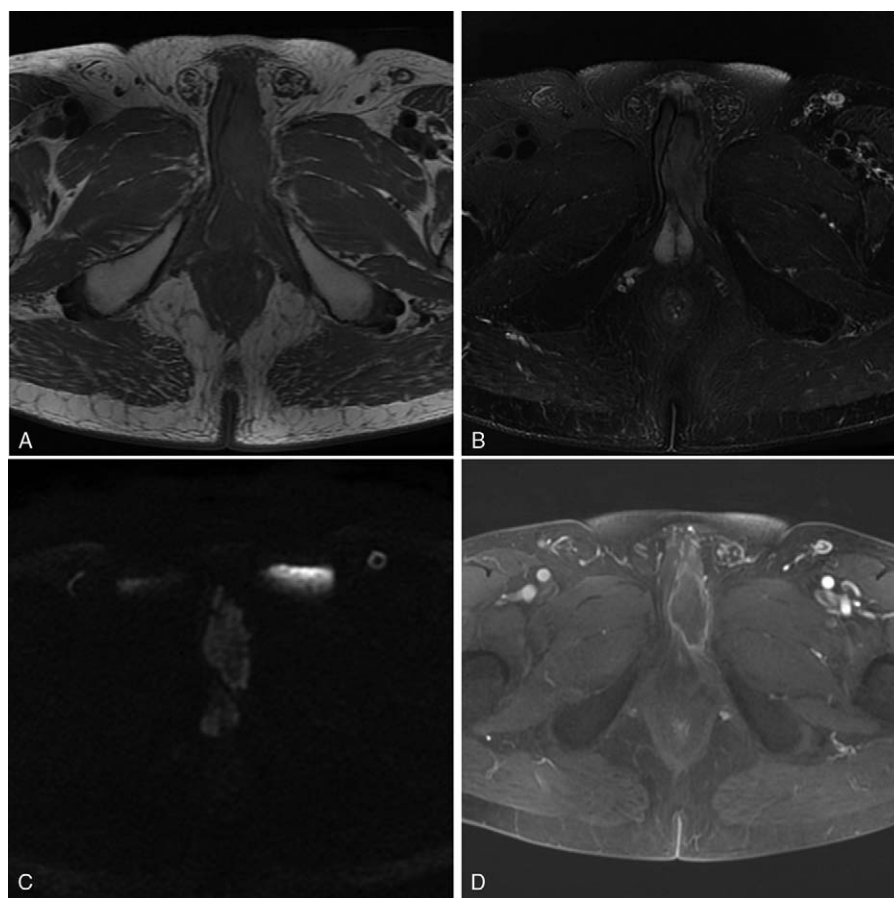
MRI of the pelvis: (A) T1-weighted image shows an isointense tissue mass located at the base of the left corpora cavernosa with irregular margins. (B) T2-weighted image shows slightly hyperintense lesion (about 5.2 cm × 2.4 cm) on the base of the left corpora cavernosa. (C) On DWI, the lesion is demonstrated hyperintense. (D) T1-weighted MR image with fat signal suppression, after Gadolinium injection, shows prominent ring enhancement in the lesion. DWI = diffusion weighted imaging, MRI = Magnetic resonance imaging.
